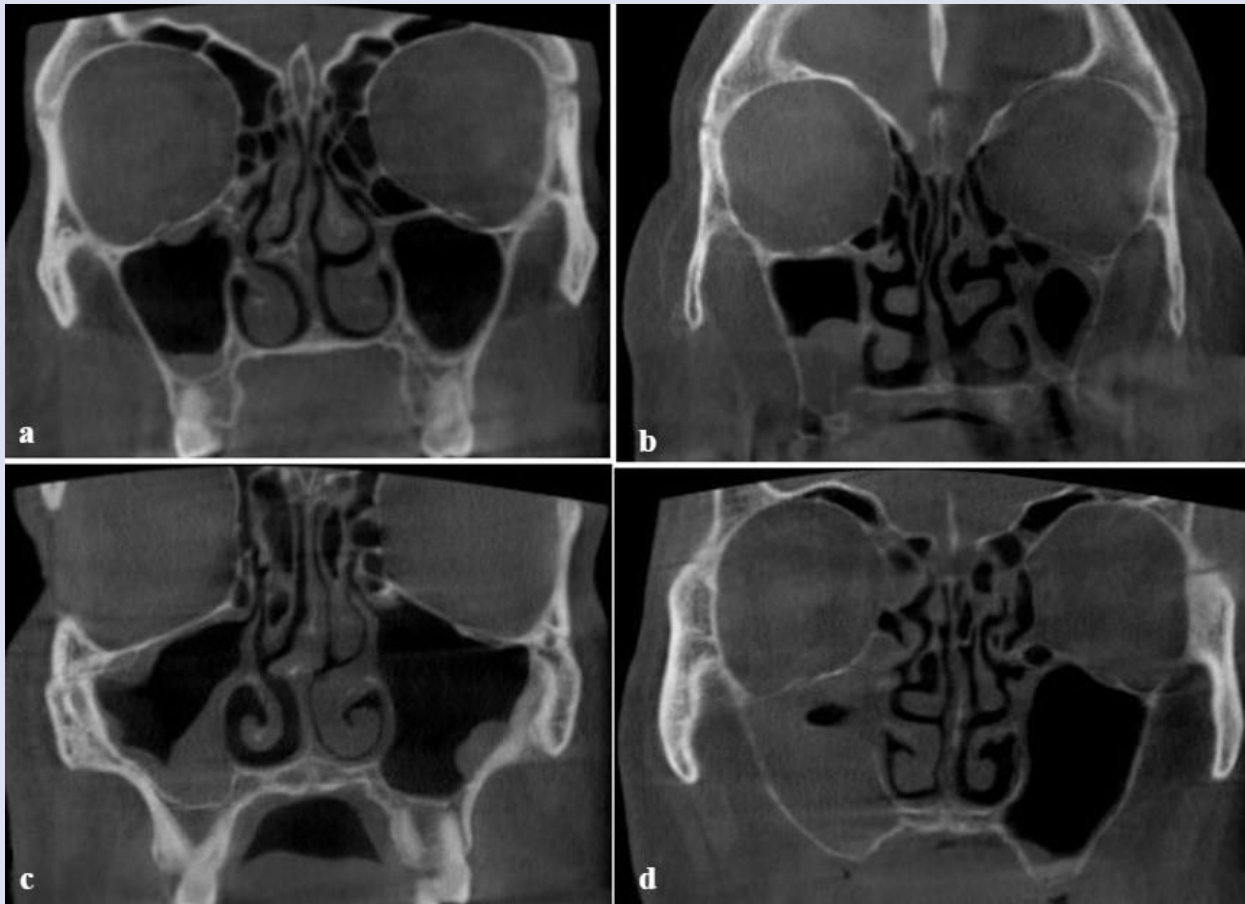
Maxillary sinus pathologies on coronal CBCT images; a. Localized mucosal thickening in the right maxillary sinus, b. Partial opacification in the right maxillary sinus and generalized mucosal thickening in the left maxillary sinus, c. Partial opacification in the right maxillary sinus and polypoidal mucosal thickening in the left maxillary sinus, d. total opacification in the right maxillary sinus.
